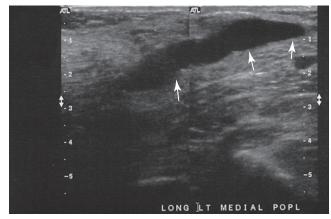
Sagittal sonogram of the medial popliteal fossa.
